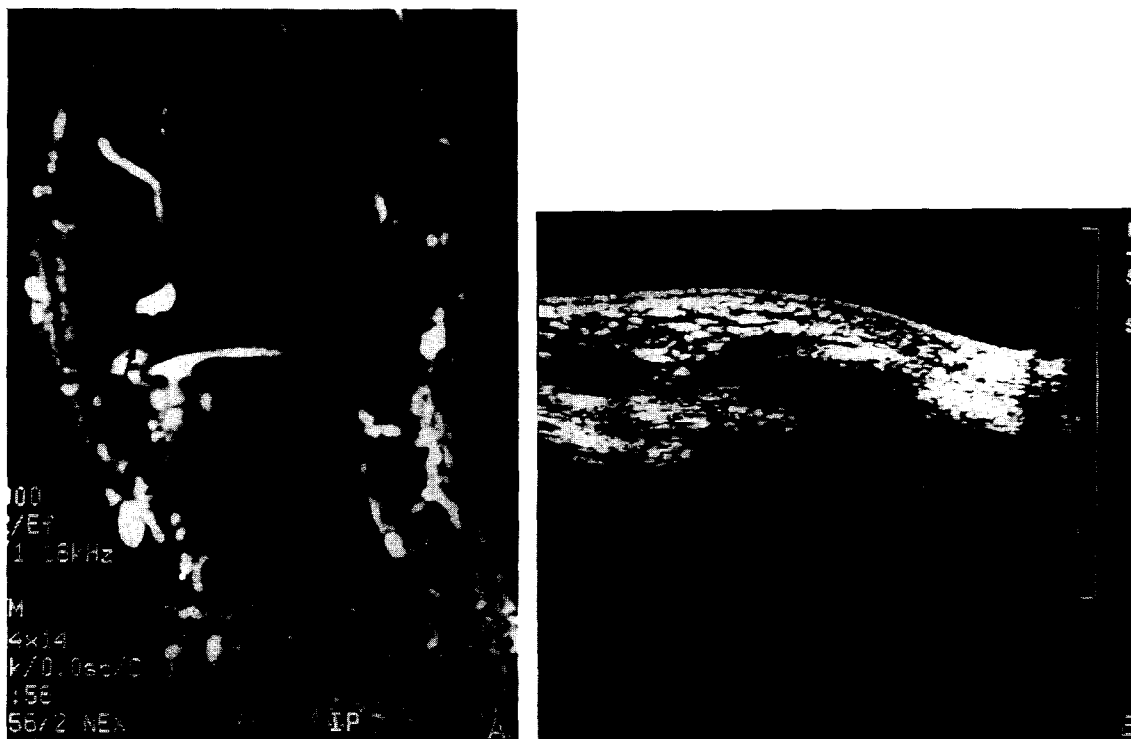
Posterior talofibular ligament: (A) Oblique coronal fat saturated MR image shows posterior talofibular ligament, which run transversely from lateral malleolus to the talus.(arrows) (B) Ultrasonography of same area, hardly visualizes the posterior talofibular ligament, due to overlying cortex of lateral malleolus. (arrows)
